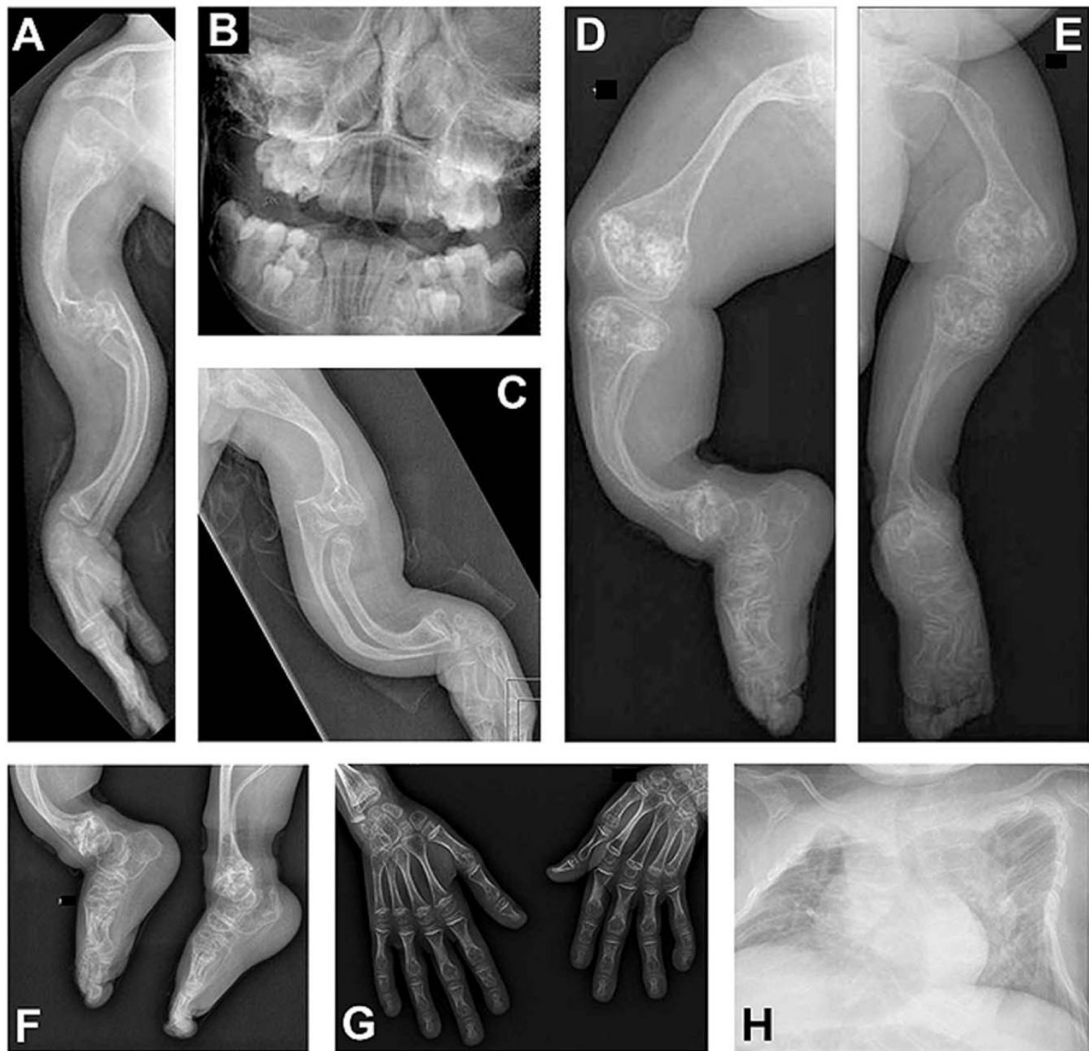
Late radiographs of Proband 3 with *CRTAP* missense mutation. *A–H*, radiographs at age 8 years, consistent with OI, found to have a homozygous missense mutation in *CRTAP*, c. 200T>C; p.Leu67Pro.
